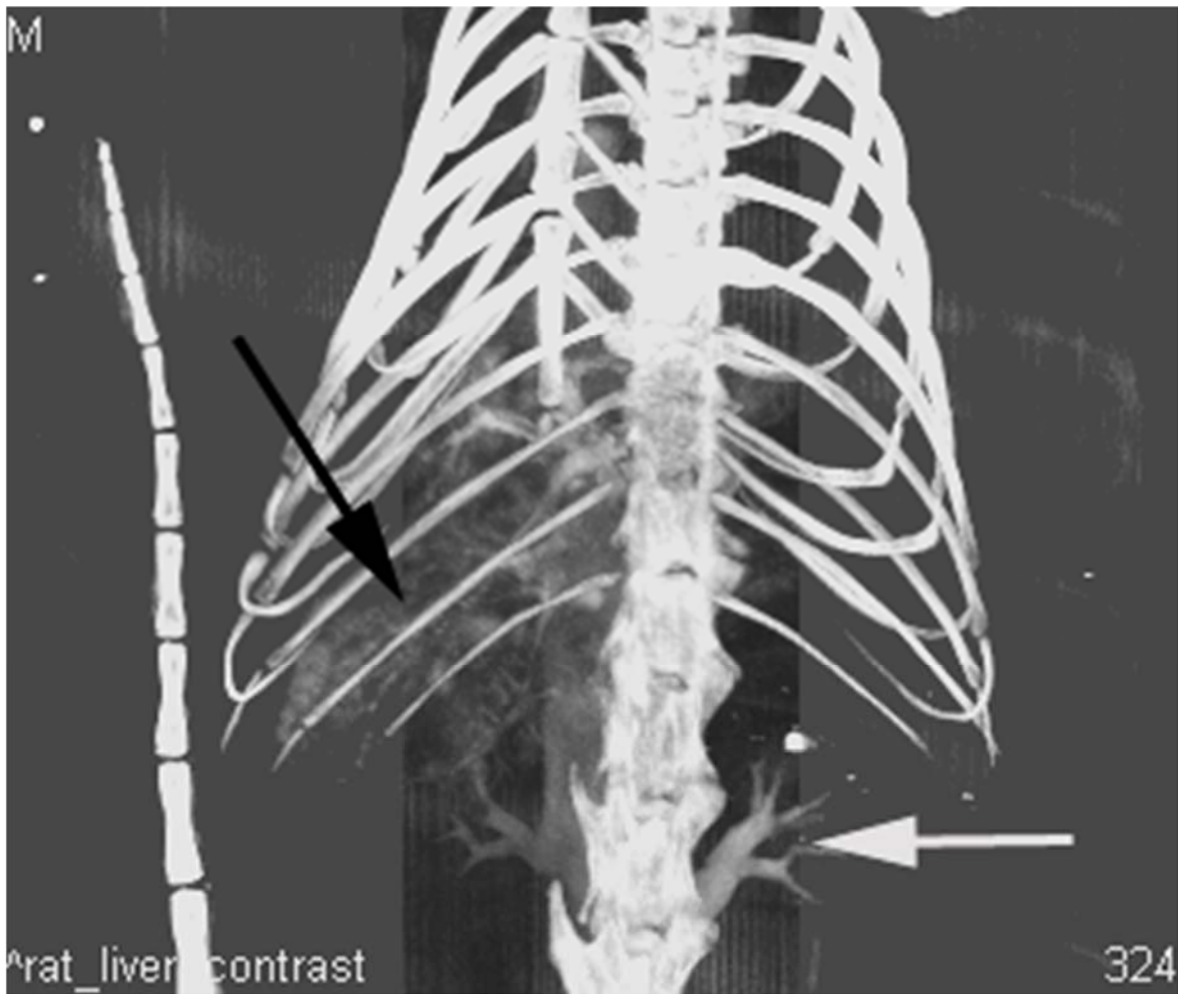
CT cholangiogram showing low-resolution outline of biliary tree (black arrow) but also showing leakage of contrast into systemic circulation as evident in the outlined renal vein (white arrow)
